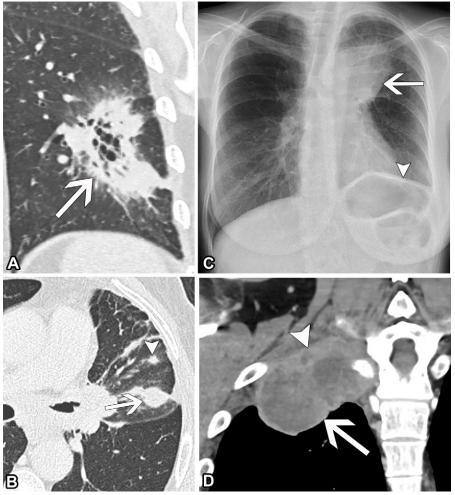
T3 lung cancer in four patients. (A) Coronal reconstruction image from an unenhanced chest CT scan (lung window) in a 71-year-old woman with NSCLC shows a mass (arrow) in the left lower lobe measuring 5.8 cm at its greater plane dimension. (B) Axial unenhanced chest CT image (lung window) in a 68-year-old man with NSCLC shows the primary tumor (arrow) in the left upper lobe associated with a separate tumor nodule (arrowhead) in the same lobe. (C) Posteroanterior chest radiograph in a 62-year-old woman with NSCLC shows a mass (arrow) in the left upper lobe that involves the left phrenic nerve (not seen) causing elevation of the left hemidiaphragm (arrowhead) due to left phrenic nerve involvement. (D) Coronal reconstruction image from a contrast-enhanced chest CT scan (soft-tissue window) in a 46-year-old man with NSCLC shows a right superior sulcus tumor (arrow) involving the chest wall and first ribs (arrowhead) but without vertebral, spinal canal, or brachial plexus involvement.
